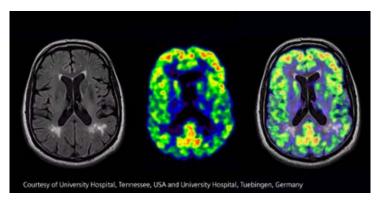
Example of PET-CT hybrid image. Positron Emission Tomography gives a quite accurate localization of metabolic activities represented in color and super projected on an X-ray Computed Tomography.
